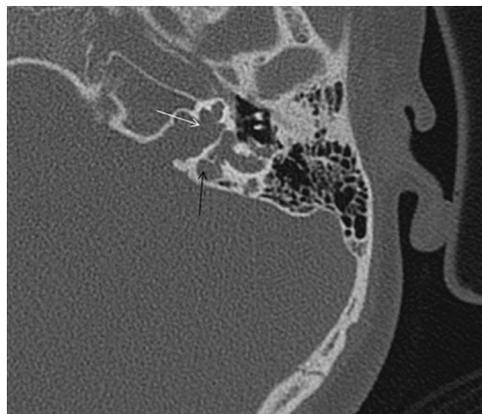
Stapes Gusher. On the axial CT Temporal bone image, there is deficiency of bone between cochlea and IAC (white arrow), the IAC is dilated and there is an EVA (black arrow). This results in a pathologic third window between the cochlea and the IAC.
